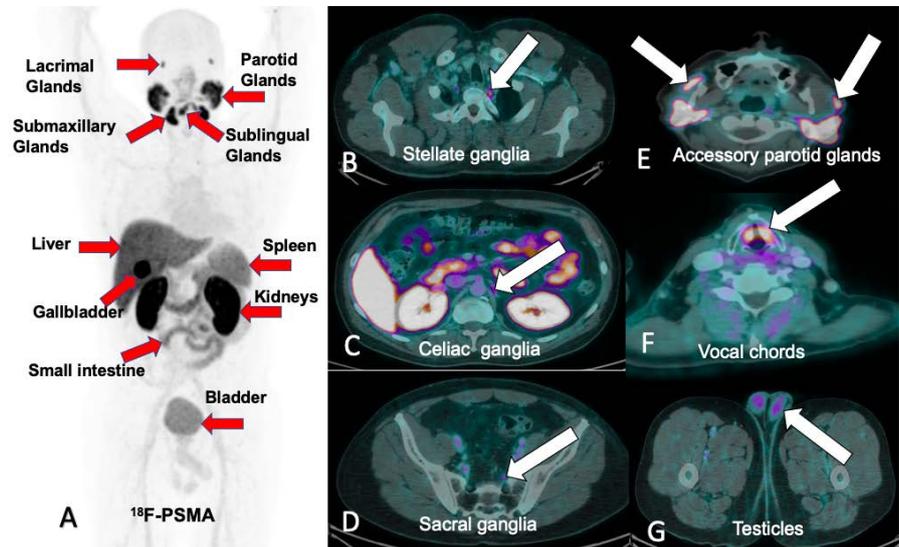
General description of the physiological uptakes with ¹⁸F-PSMA. (A) MIP in anterior showing physiological uptake in the lacrimal, parotid, submaxillary and sublingual glands, liver, gallbladder, spleen, small intestine and bladder (red arrows). PET/CT fusion in axial section with physiological uptakes in (B) stellate ganglia (C) celiac ganglia (D) presacral ganglia (E) bilateral accessory parotid glands (F) vocal chords and (G) testes.
